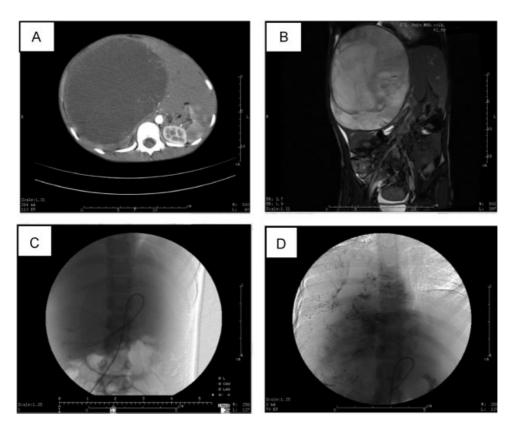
(A and B) CT and MRI scans of case 1 show an unresectable mass in the liver. (C) Digital subtraction angiography displays the tumor's blood supply of "holding ball." (D) The feeding artery of the tumor was embolized. CT, computed tomography; MRI, magnetic resonance imaging.
